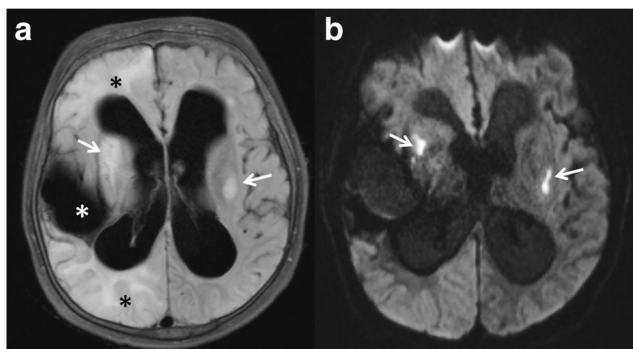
A 9-year-old female affected by methyl malonic acidemia. Flair images demonstrate alterations in the bilateral putamen (a, *arrows*), corresponding to restricted diffusion on DWI (b, *arrows*). A remote stroke in the right middle cerebral artery distribution is identified (a, *white asterisk*). Cortical/subcortical anomalies are also seen in the right frontal lobe and right posterior periventricular white matter (a, *dark asterisks*)
